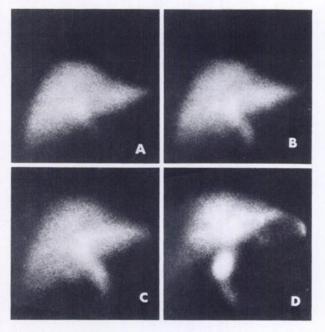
Hepato-biliary scintigraphy with Tc-99m diethyl-IDA in a patient with stones in the gallbladder and common bile duct: (A, B, C) 20, 30, and 40 min after injection, respectively. Postoperative visualization of site of choledochoduodenostomy 40 min after injection (D).
